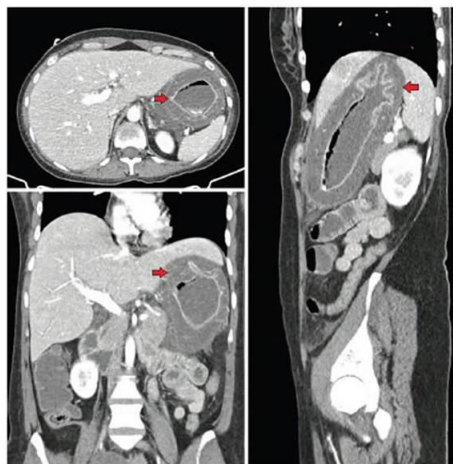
Posterior CT scan of the abdomen and pelvis showing diffuse thickening of the entire gastric wall (arrows)
